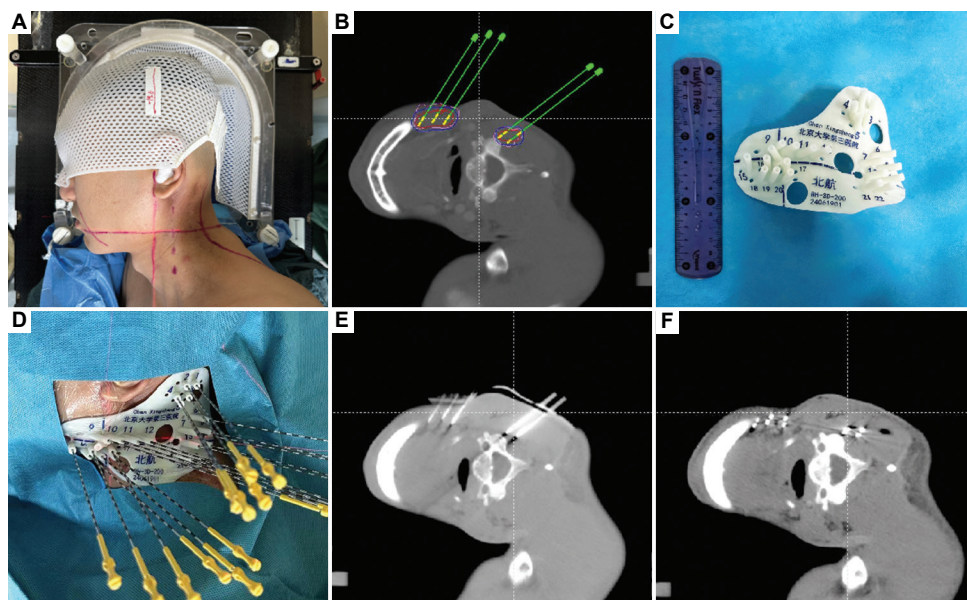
The three-dimensional-printing non-co-planar template utilized in computed tomography-guided iodine-125 radioactive seed implantation. (A) Pre-operative assessment. (B) Print personalized 3D-printing non-co-planar template through 3D printing. (C) Pre-operative planning design. (D) Insert needles. (E) Verify needle positions. (F) Perform ¹²⁵I seed implantation.
